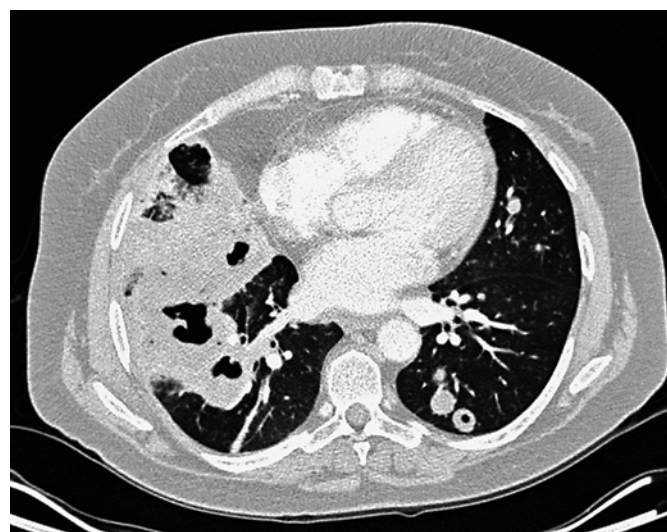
Chest CT in another patient with granulomatosis with polyangiitis showing areas of consolidation, with cavitated nodules and cavitation within the consolidation.
